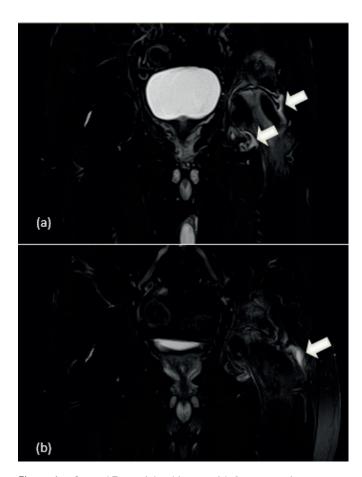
Coronal T2 -weighted image with fat suppression at baseline (a) revealing increased femoral head bone marrow intensity that reflects bone oedema and effusion (white arrows). Follow- up MRI (b) demonstrate reduction of signal intensity on bone marrow and reduction of effusion (white arrow)
